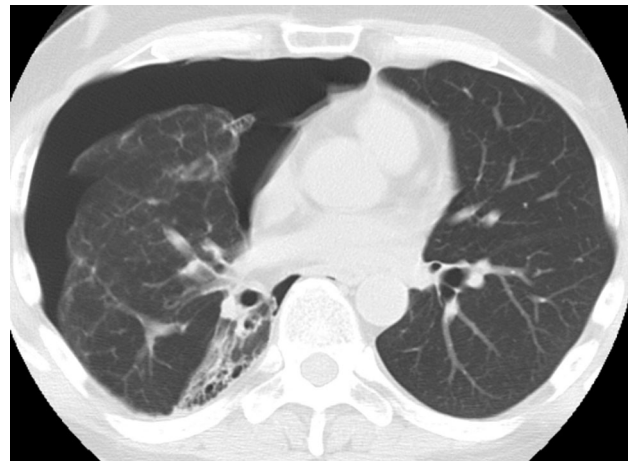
Right pneumothorax occurred in 50-year-old man with interstitial lung disease 6 months after left single lung transplantation. Chest computed tomography shows pneumothorax of the native right lung
